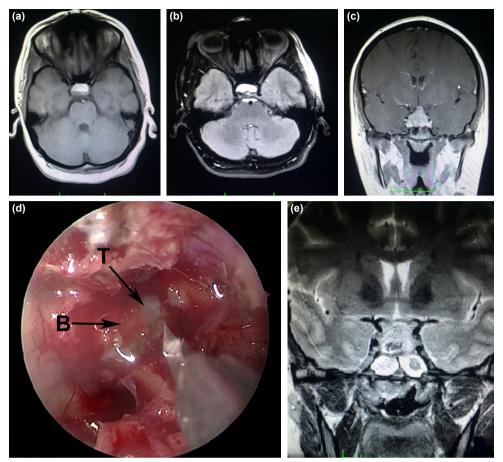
A 17-year-old female patient presented with pituitary apoplexy. Pre-operative T1-axial magnetic resonance imaging (MRI) slices (a and b) show hyperintense blood in the sellar region, T1-coronal MRI slice (c) shows compression of optic chiasm. She underwent tumor removal using endoscopic endonasal transsphenoidal approach. Tumor was removed with intrasellar blood products (d). Post-operative T2-coronal MRI (e) confirmed total resection of pituitary adenoma. T: Tumor, B: Blood products.
